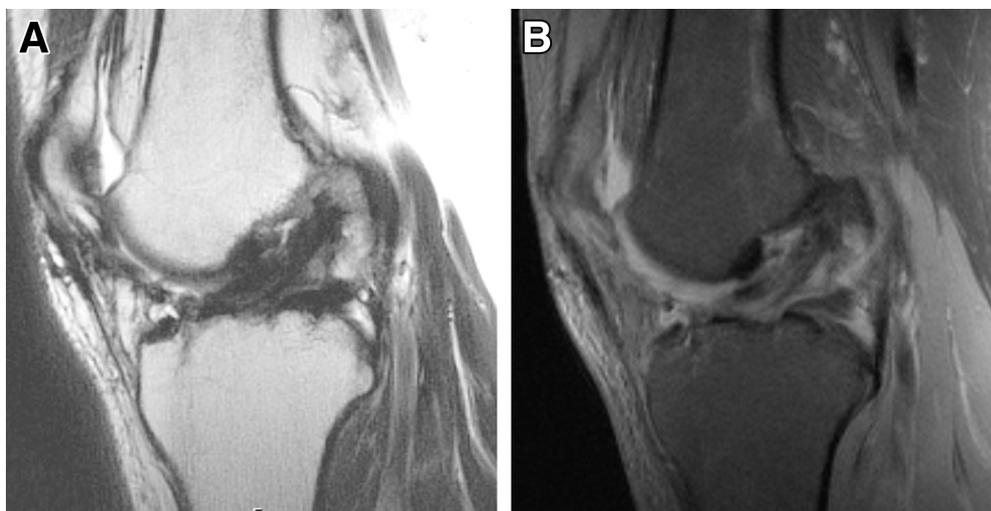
Postoperative magnetic resonance imaging scans of patient 8 at 4.9 years' follow-up. The sagittal T1 (A) and T2 (B) images show a homogeneous signal in the ligament with continuity of the fibers from the tibial footprint to the femoral footprint. This patient had stable Lachman and pivot-shift examination findings.
